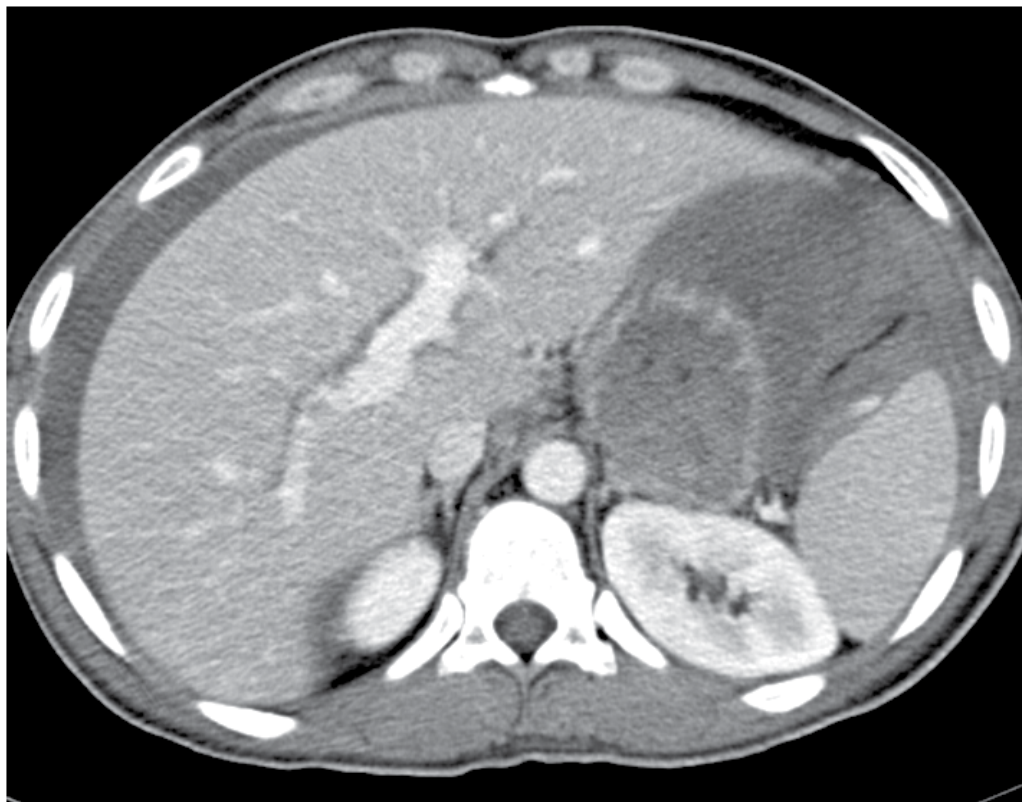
CT scan revealing intraperitoneal bleeding following subcostal percutaneous liver biopsy. The bleeding was successfully managed conservatively
